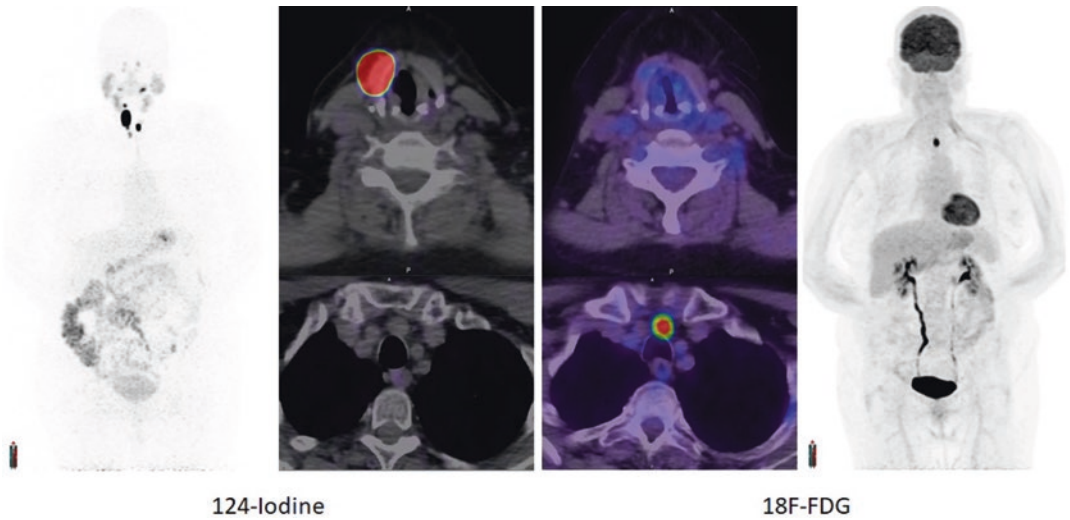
A patient with Hurthle cell carcinoma following thyroidectomy. Stimulated (following T4 withdrawal) I-124 PET/CT (left) shows residual functioning thyroid tissue in the bilateral thyroid bed with no FDG avidity.
